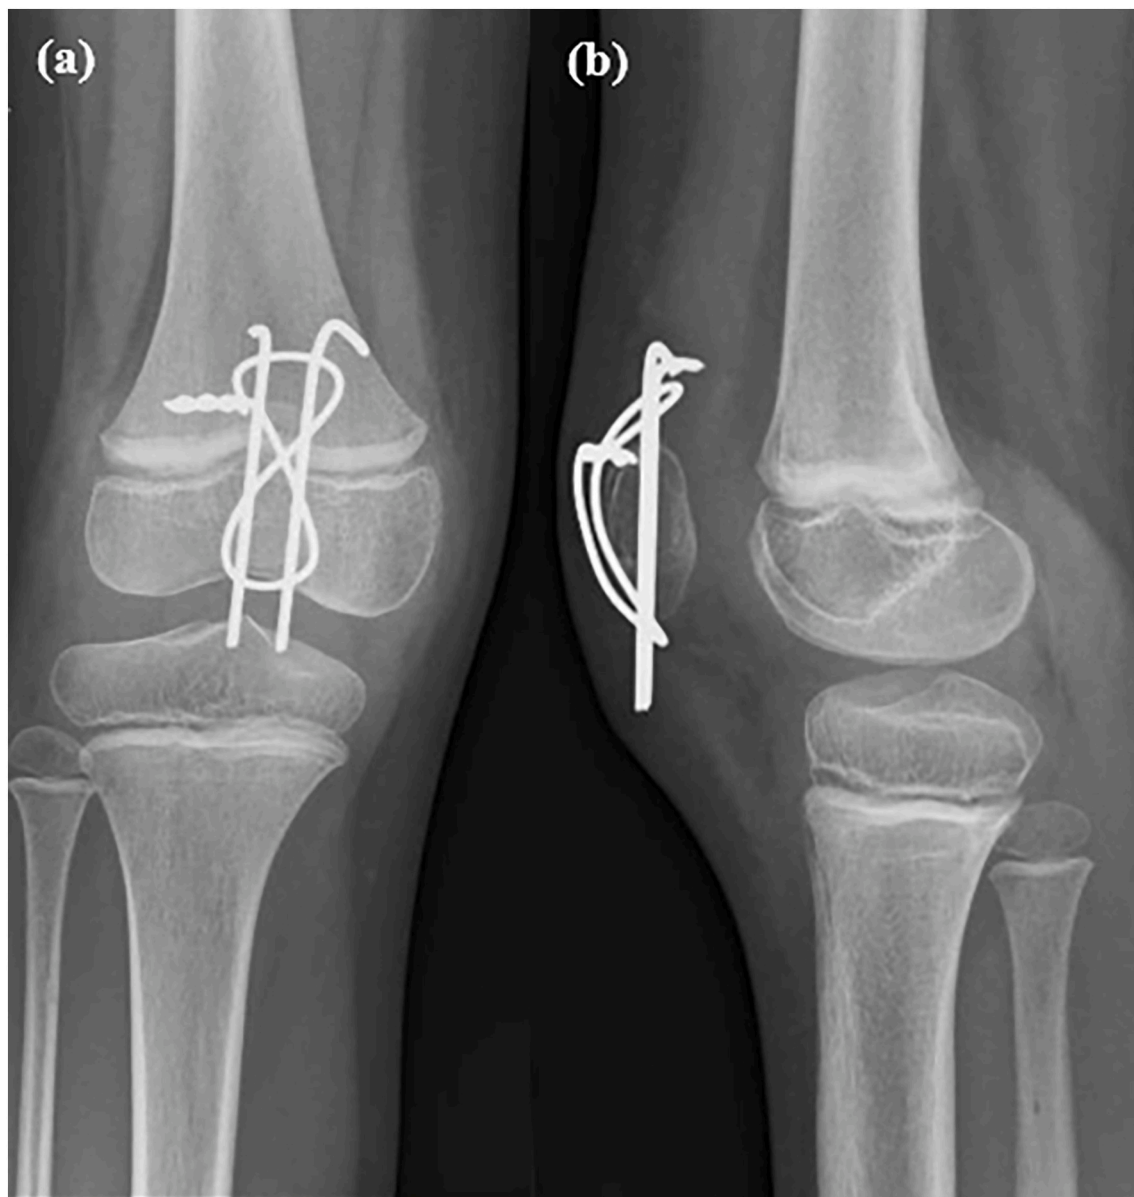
(a) Anteroposterior and (b) lateral weight bearing knee radiographs 2 months after operation showing a healed patella fracture.
